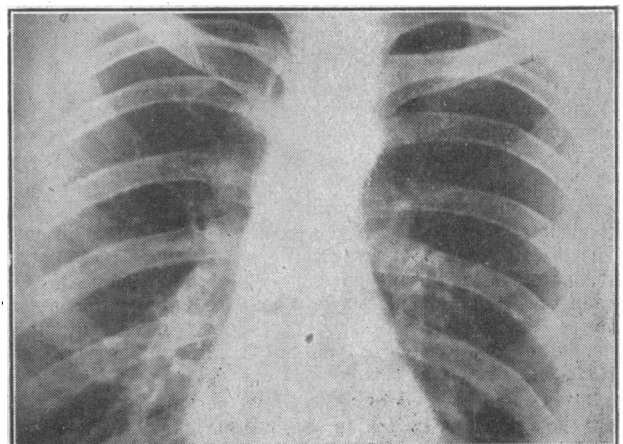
Case 1: X-ray appearances after treatment.
